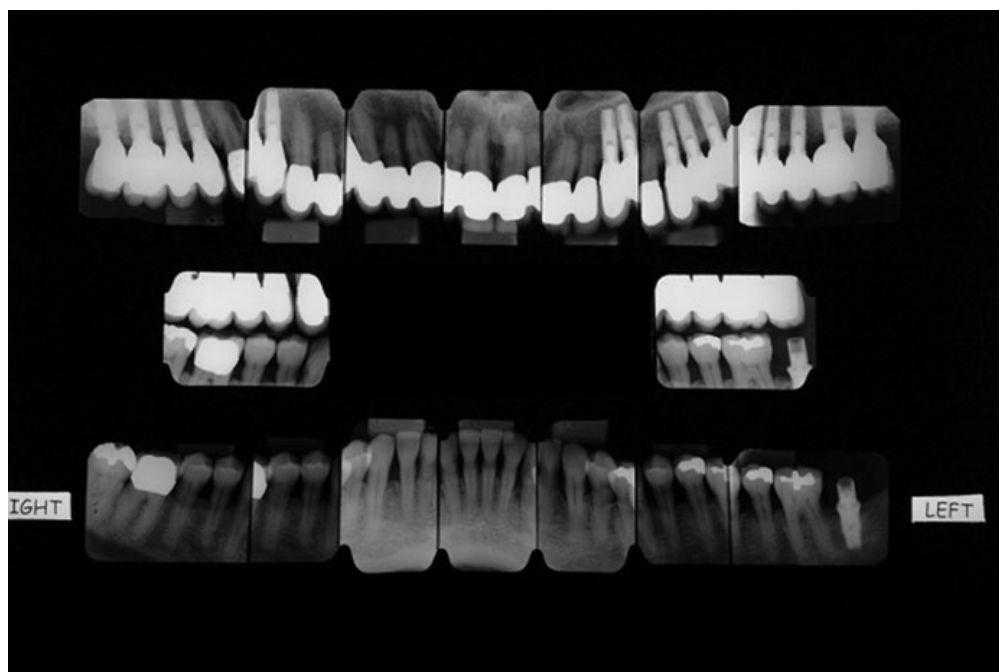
(E) Final radiographs.
